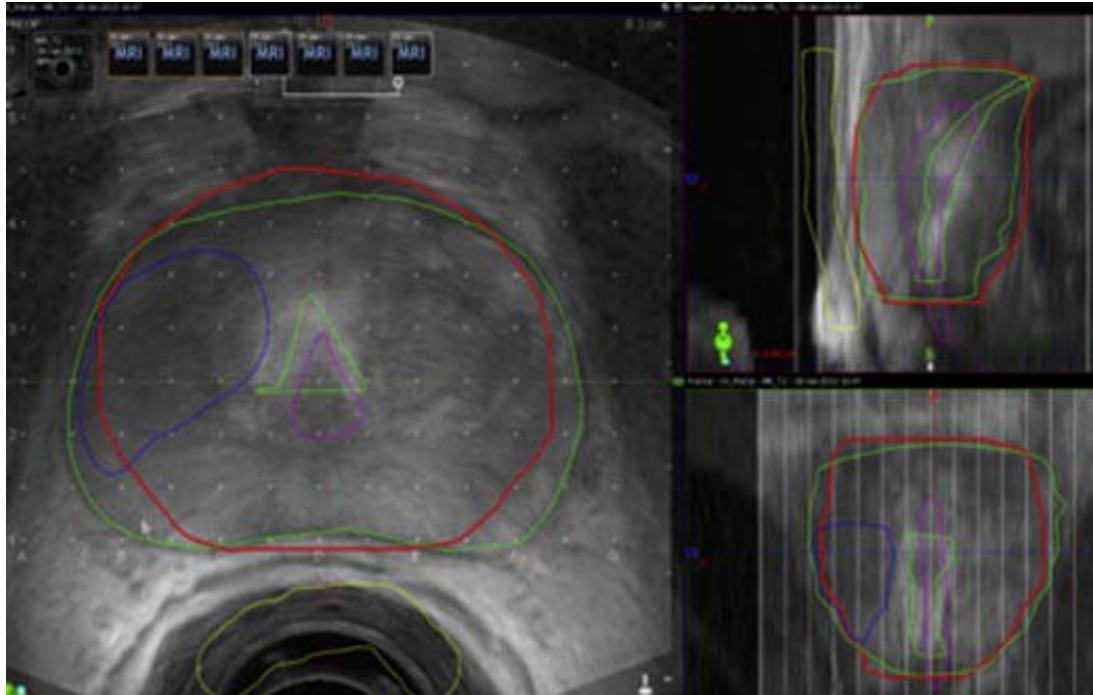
Three-way fusion of eMRI, intraoperative TRUS, and preoperative TRUS (eMRI prostate, green; TRUS prostate, red; and DIL, blue). Note slight deformation of prostate by endorectal coil. eMRI = endorectal MRI; TRUS = transrectal ultrasound; DIL = dominant...
